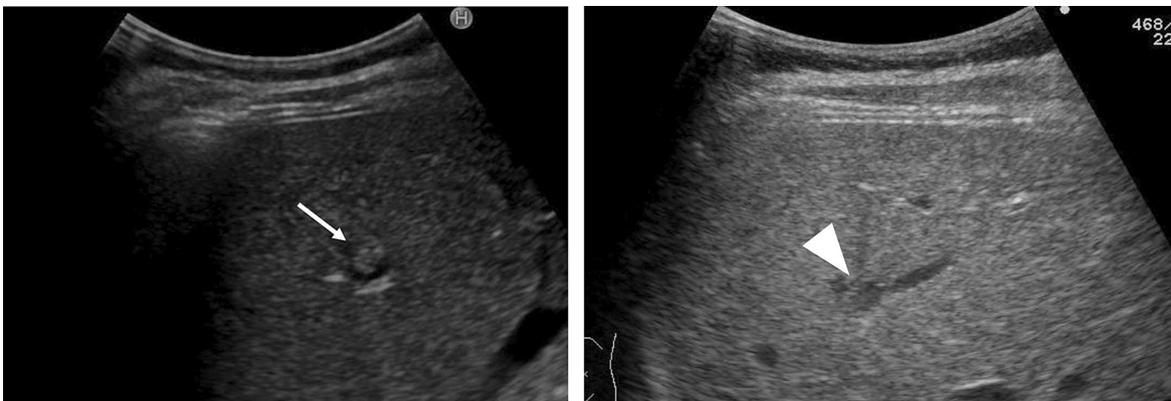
Transabdominal ultrasound findings
